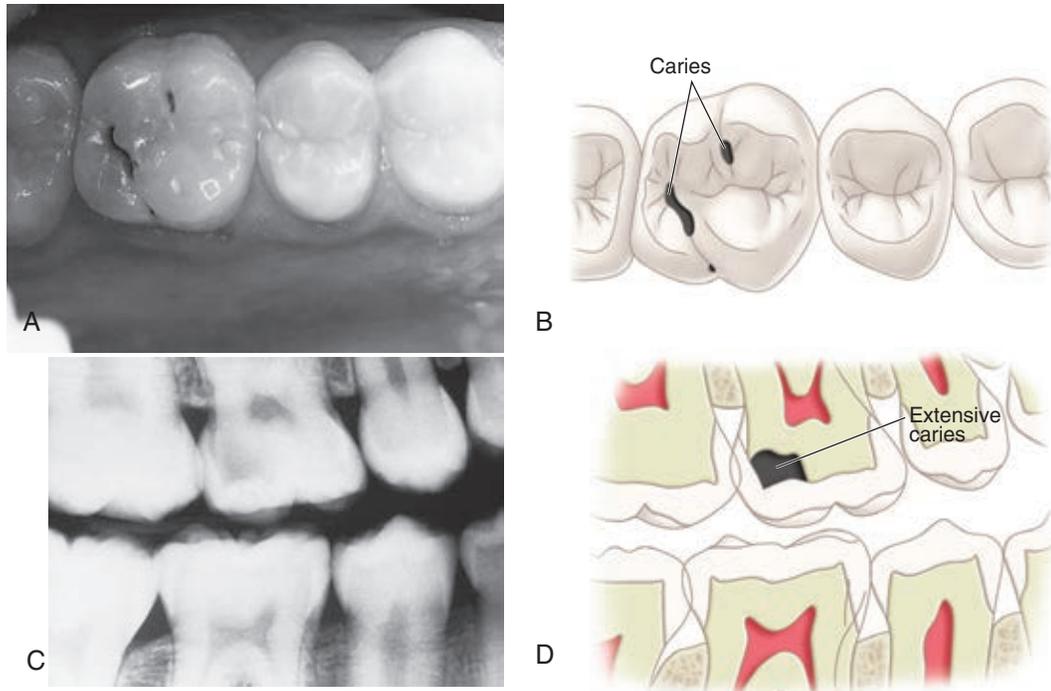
Example of occlusal caries that is much more extensive than is apparent clinically. A and B, Clinical example. C and D, A bitewing radiograph further reveals an extensive area of demineralization undermining the distofacial cusp.
